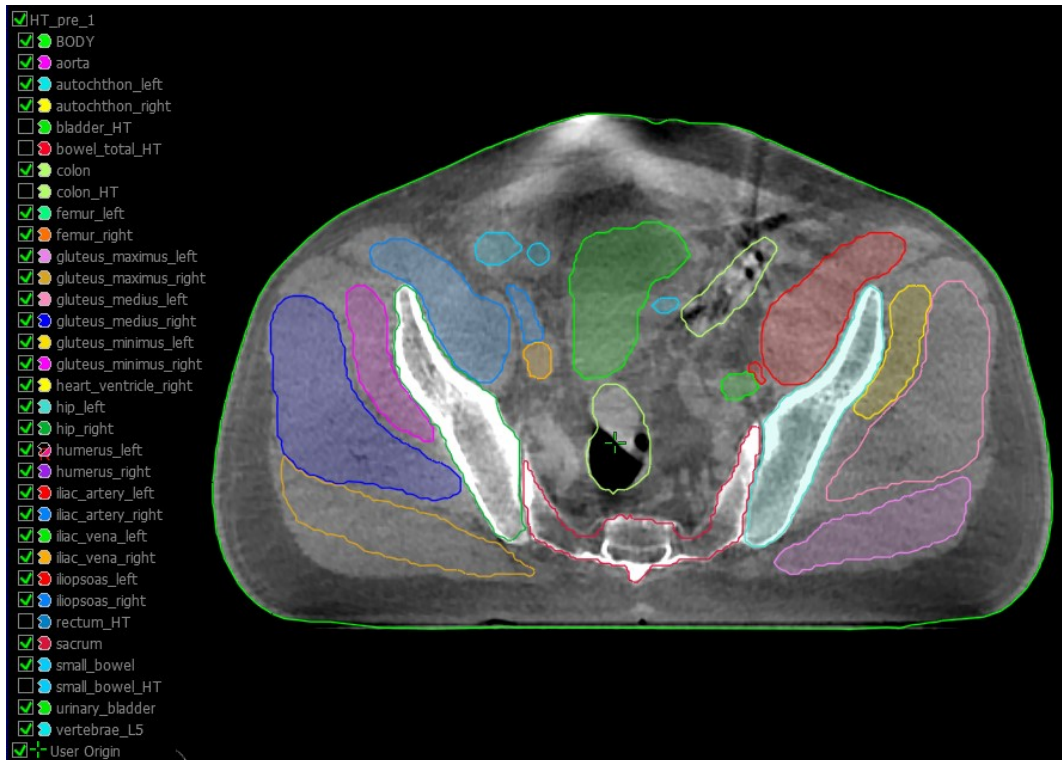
A CBCT slice in one patient including TotalSegmentator's segmentations checked off in the list. The remaining structures are copies revised by delineator one, not visualised on the scan.
